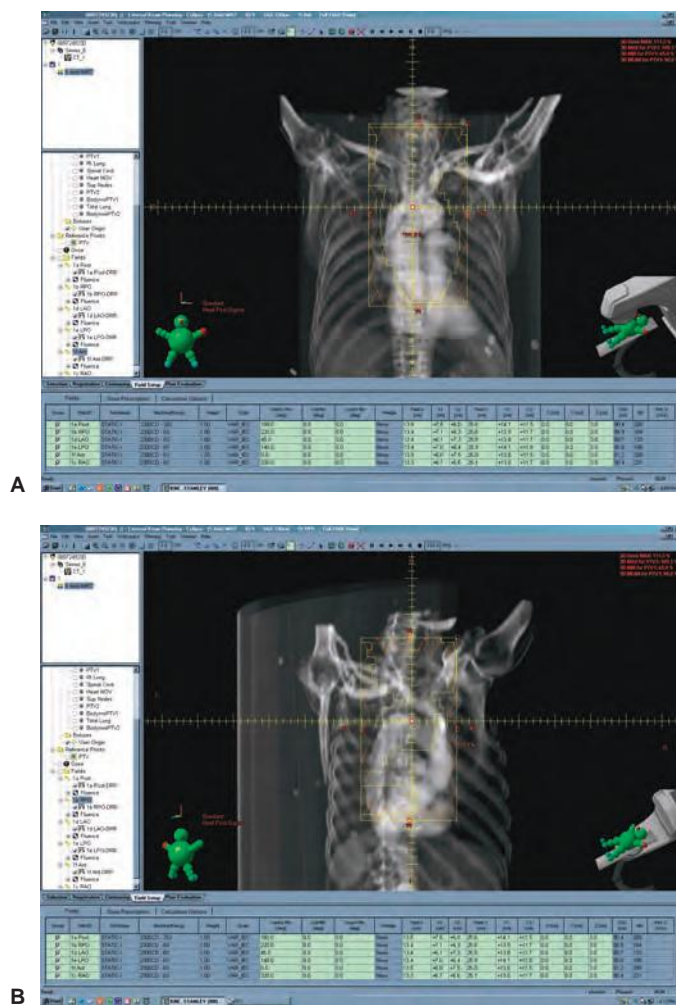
A: Digitally reconstructed radiograph (DRR) anterior field. B: DRR posterior oblique.
